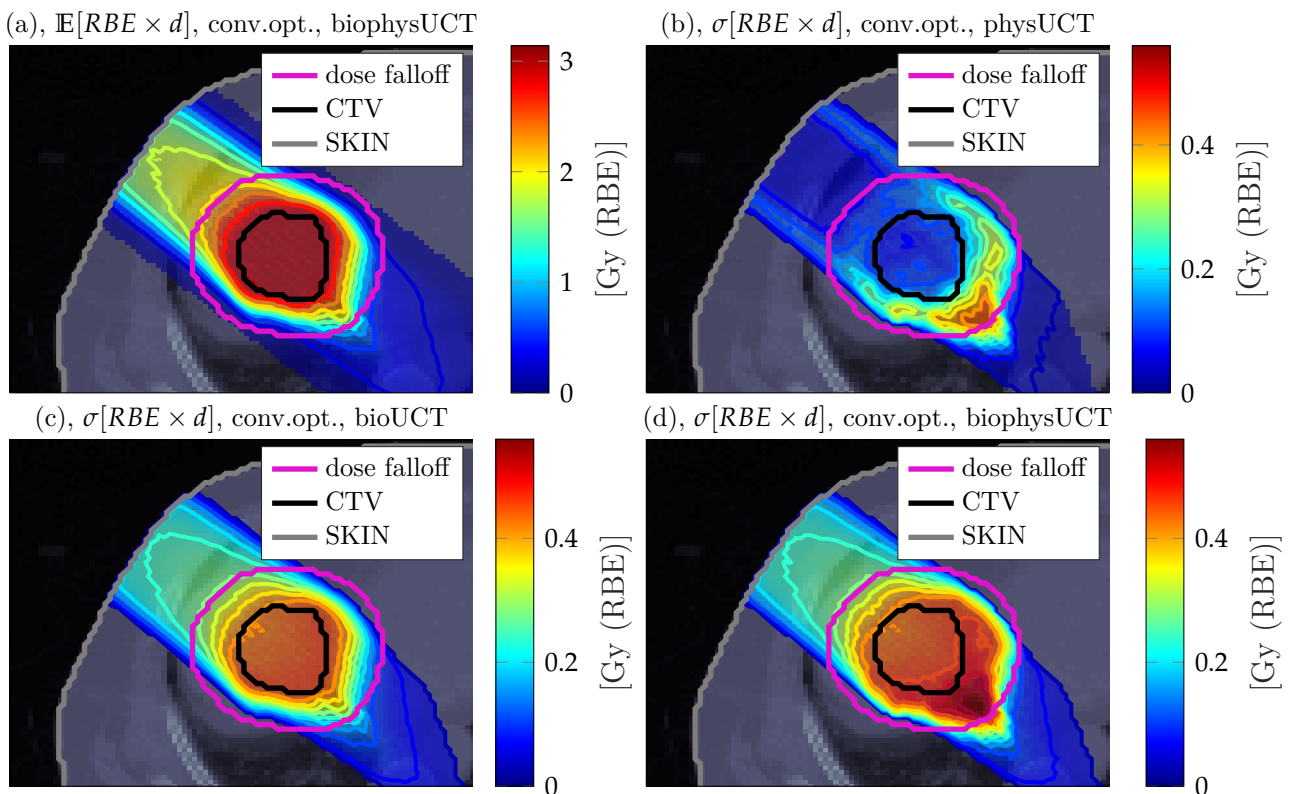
Uncertainty quantification of a liver treatment plan on the basis of conventional optimization. The transversal CT image is superimposed by transparent dose colorwash, solid iso-dose lines and solid contours. Figure (a) shows the expected RBE weighted dose ($\mathbb{E}[RBE \times d]$) assuming biological and physical uncertainties (biophysUCT). Figure (b) shows the uncertainty in the RBE weighted dose originating from physical uncertainties (physUCT) whereas Figure(c) highlights the uncertainty in dose stemming from biological uncertainties (bioUCT). Figure (d) shows the uncertainty ($\sigma[RBE \times d]$) of the combined consideration of physical and biological uncertainties (biophysUCT).
